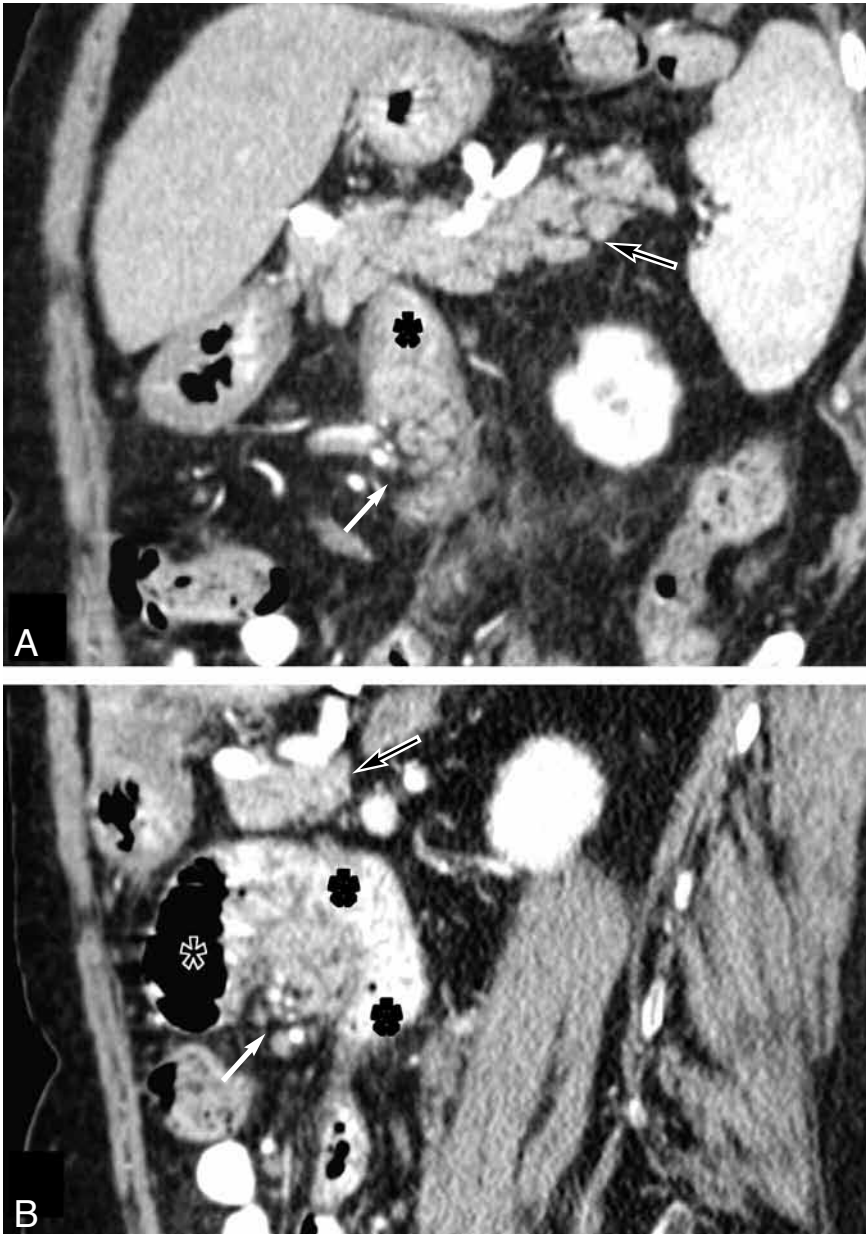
Contrast enhanced CT obtained 6 months after admission demonstrates spontaneous recovery, with disappearance of fluid collections. On MPR coronal oblique (A) and sagittal (B) view, ectopic pancreatic lobulation and enhancement (white arrows) is well visible and appears similar to normotopic pancreas (white arrow). HP is adjacent to the duodenojejunal flexure (black asterisks).
